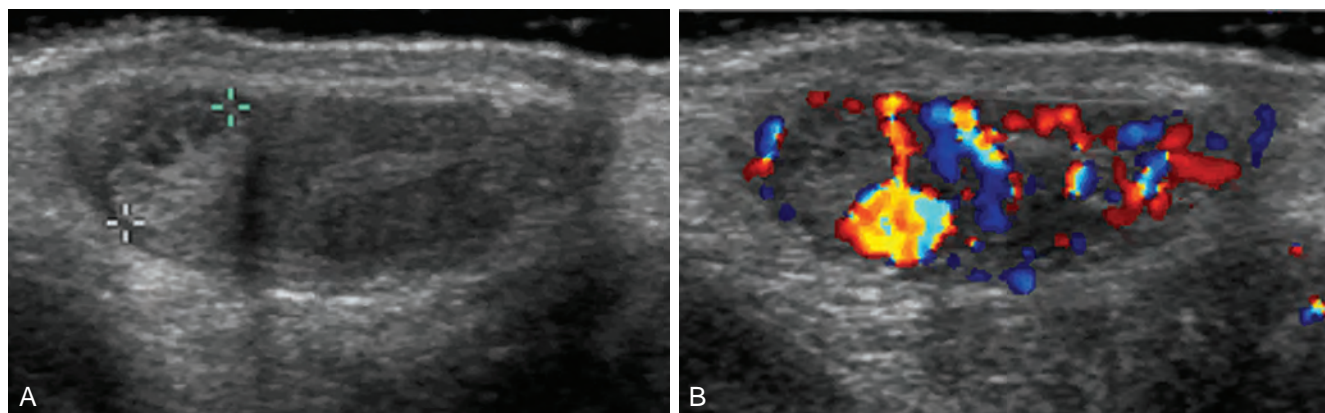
Torsion of testicular appendage. Color Doppler ultrasonography demonstrates (A) enlarged and heterogeneous appendage and (B) absent flow despite increased flow to the epididymis and testis.
